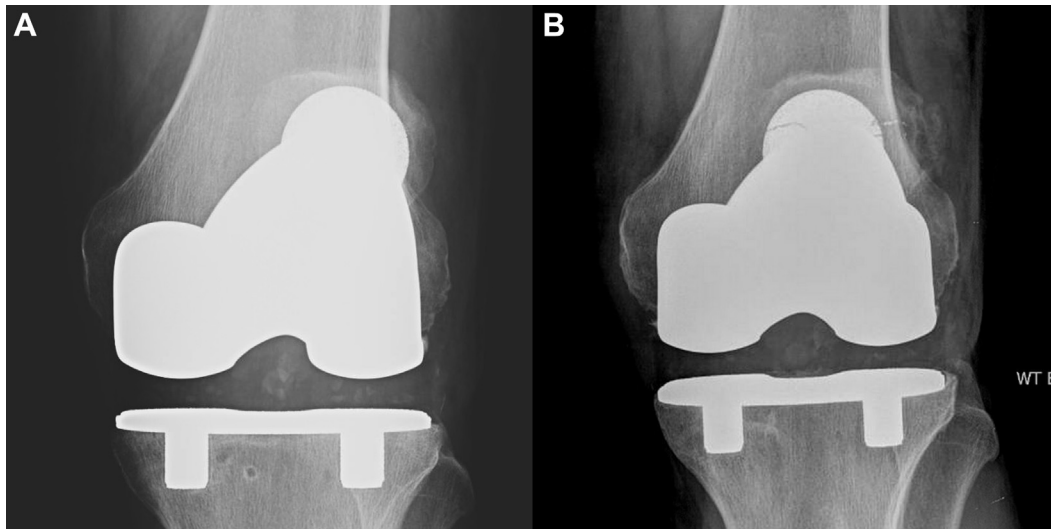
Anteroposterior radiographs of the knee before (A) and after (B) patellar component fracture in a 59-year-old man who underwent uncemented total knee arthroplasty (TKA) with a cementless tantalum monoblock design. Component fracture was first observed at 1.4 years postoperatively.
